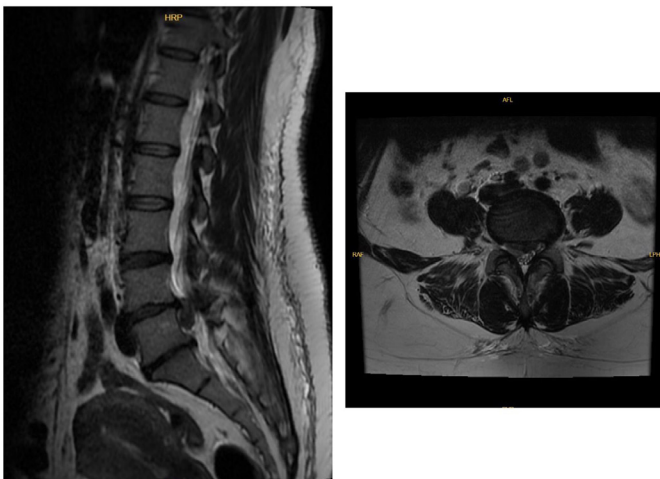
MRI findings of LDH
